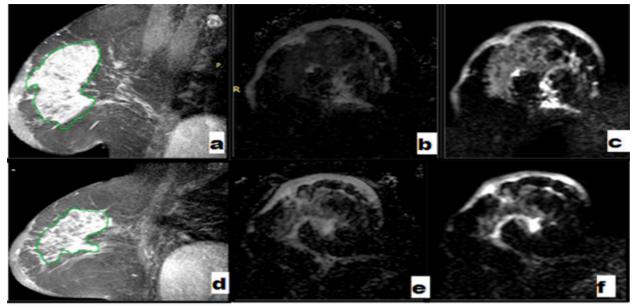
Pre-neoadjuvant MRI findings: a: Post contrast fat suppression 3DVolumetric MIP showing retroareolar intense in-homogenously enhancing irregular outer surface mass lesion. b: ADC images shows a fairly defined large right breast retroareolar and upper outer quadrant speculated outer surface mass lesion with low "dark" signal denoting restricted diffusion with ADC value (10⁻³ mm²/s =0.82). C: axial DWIs: Presents the retroareolar mass lesion showing diffuse variable degrees of bright "high" signal in the DWIs. Average pretreatment volume was about 260-280 cm³. The central necrotic volume within the tumor was 30-40 cm³.
